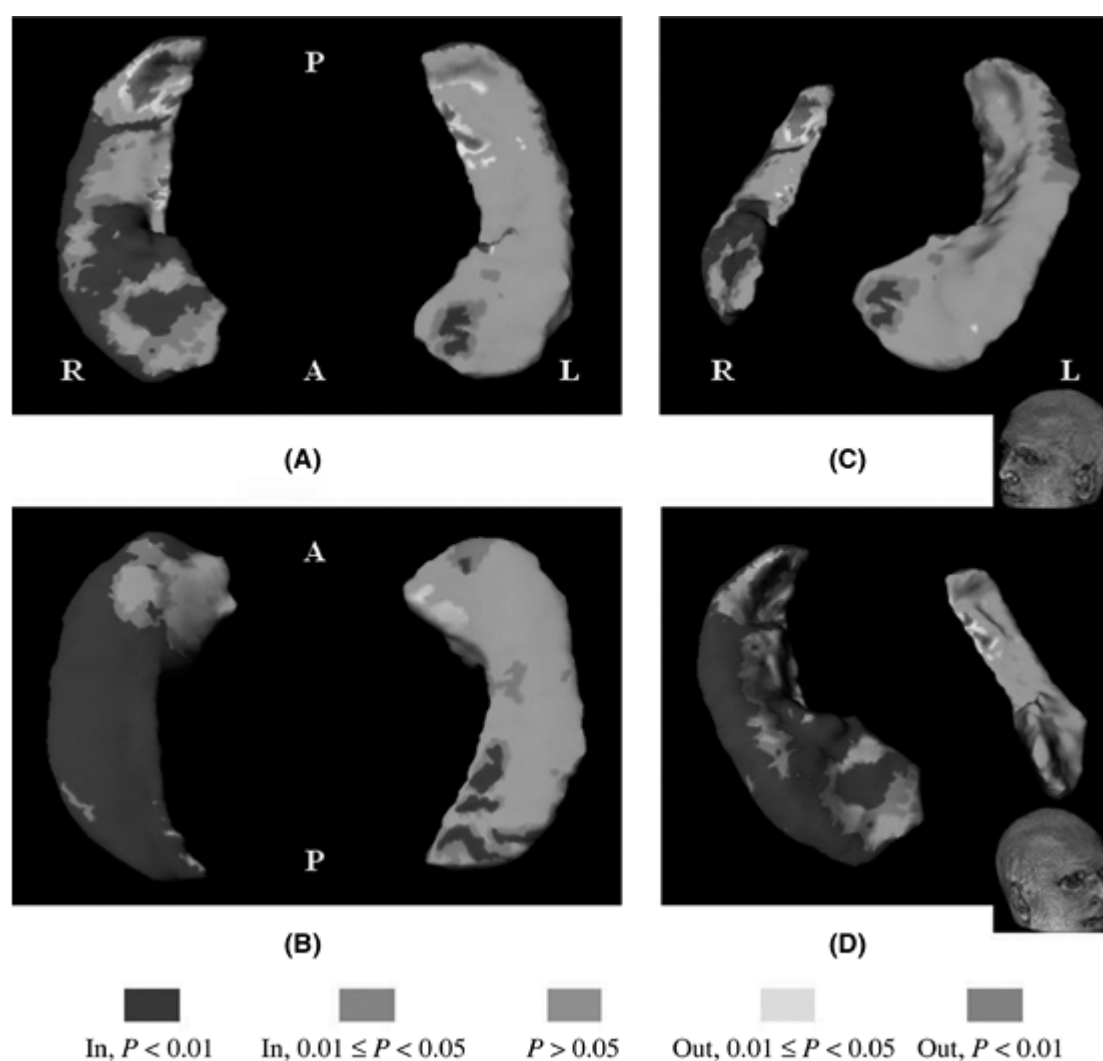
Large-deformation, high-dimensional brain mapping reveals bilateral hippocampal deformity in right mesial temporal lobe epilepsy patients. Similar bilateral changes were found in left temporal lobe epilepsy patients. Inward deviation is shown in purple ($p < .01$) and turquoise ($.01 = p < .05$). Outward deviation is shown in red ($p < .01$) and yellow ($.01 = p < .05$). A: View from above. B: View from below. C: View from a perspective slightly above and to the left of a midline plane, showing the top side. D: View from a perspective slightly above and to the right of a midline plane, showing the top side. A, anterior; L, left; P, posterior; R, right. (From Hogan RE, Wang L, Bertrand ME, et al. MRI-based high-dimensional hippocampal mapping in mesial temporal lobe epilepsy. *Brain*. 2004;127:1731–1740, with permission.) (See the color insert.)
